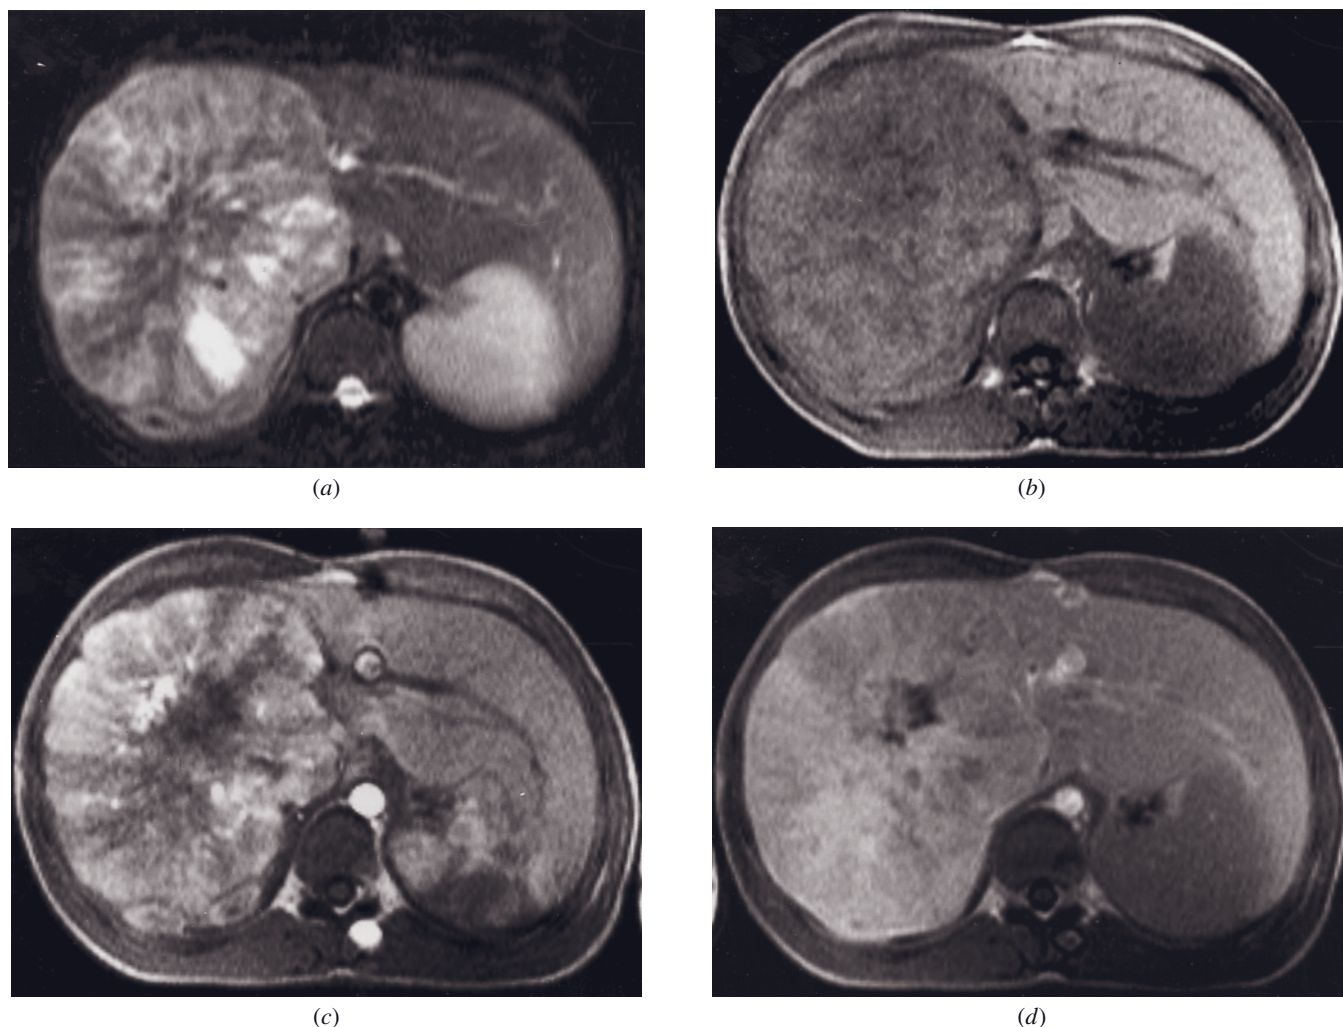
Fibrolamellar carcinoma. Fat-suppressed T2-weighted ETSE (a), SGE (b), and immediate (c) and 10-min postgadolinium SGE (d) images. A 14-cm fibrolamellar hepatocellular carcinoma is present in this adolescent male with no history of liver disease and 1-yr duration of gynecomastia. The tumor is heterogeneously hyperintense on the T2-weighted image (a) with the central radiating scar largely low in signal intensity and hypointense on the T1-weighted image (b) with the central scar also low in signal intensity. On the immediate image (c), the tumor exhibits diffuse moderate heterogeneous enhancement with negligible enhancement of the radiating scar. On the 10-min image (d), the bulk of the tumor has become isointense with background liver. Portions of the central scar are higher in signal intensity than surrounding tissue, whereas other parts remain low in signal. In contrast to FNH, the scar in fibrolamellar HCC is much larger and exhibits more heterogeneous signal on T2 and early and late postgadolinium images.
